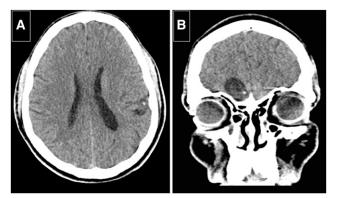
Computed tomography showing a vesicular lesion in the parietal region of the left hemisphere and in the anterior temporal region (case 3).
